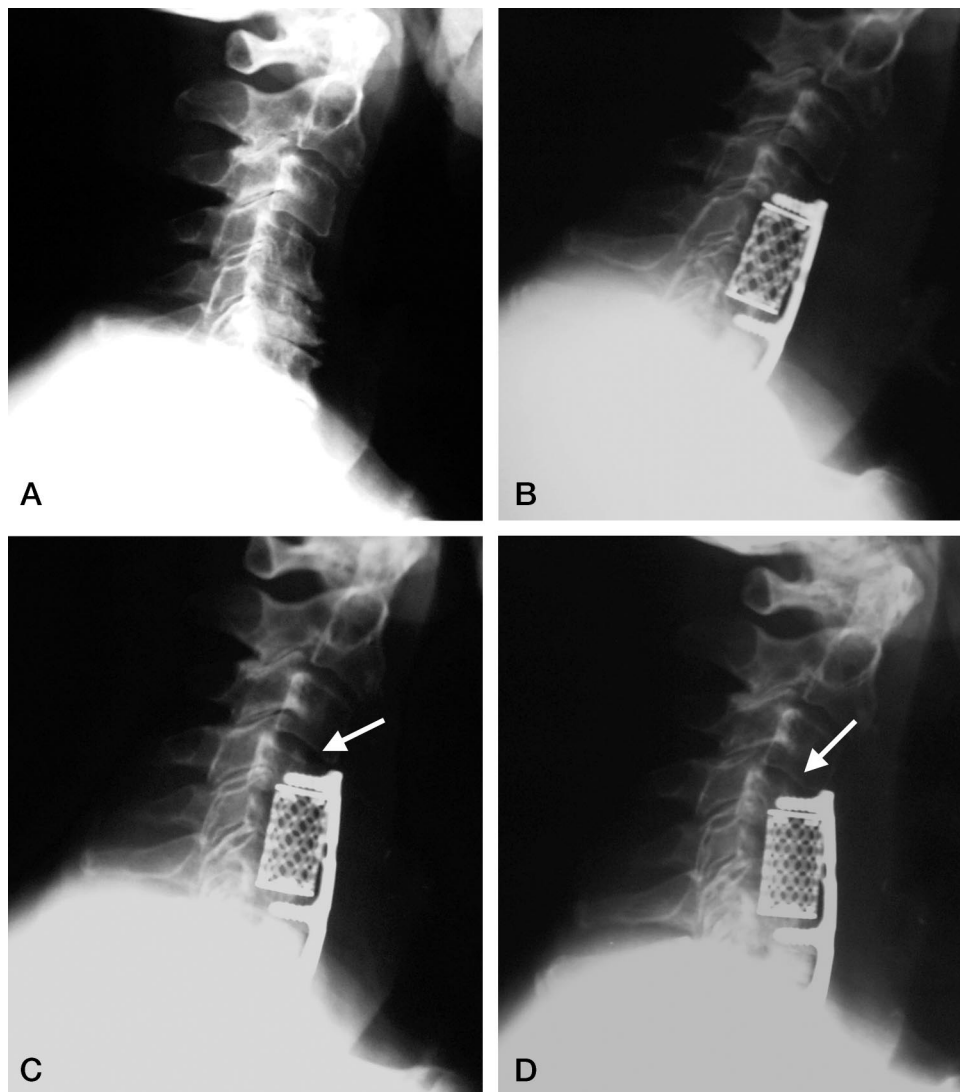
A 70-year-old male with cervical spondylosis and myelopathy. A, Preoperative lateral radiograph showing spondylosis and severe disc space collapse with kyphosis. B, Postoperative lateral radiograph at 2 weeks showing the Syn-Mesh cage placed from C4–C6 at the level of the C5 corpectomy, and a fibular allograft placed at the level of C6–C7 where a discectomy was performed. The Synthes CSLP plate was placed from C4–C7, with screws inserted distally at C6 and C7. C, Postoperative lateral radiograph at 6 weeks showing superior subsidence of the cage (arrow) into the C4 vertebral body. D, Postoperative lateral radiograph at 9 weeks showing further subsidence of the cage (arrow) and screws into C4, and further collapse into kyphosis.
